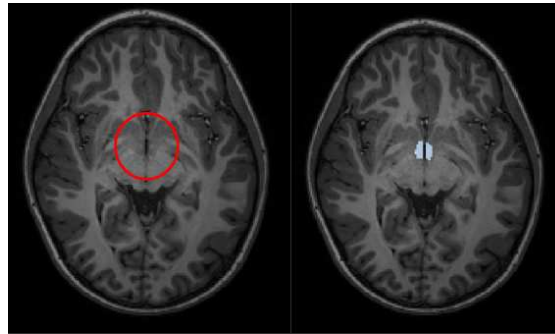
Hypothalamus on the adult brain on a T1w MR image. Highlighted on the left, we have the region where the hypothalamus is located. On the right, we can see more clearly the structure through the manual segmentation
